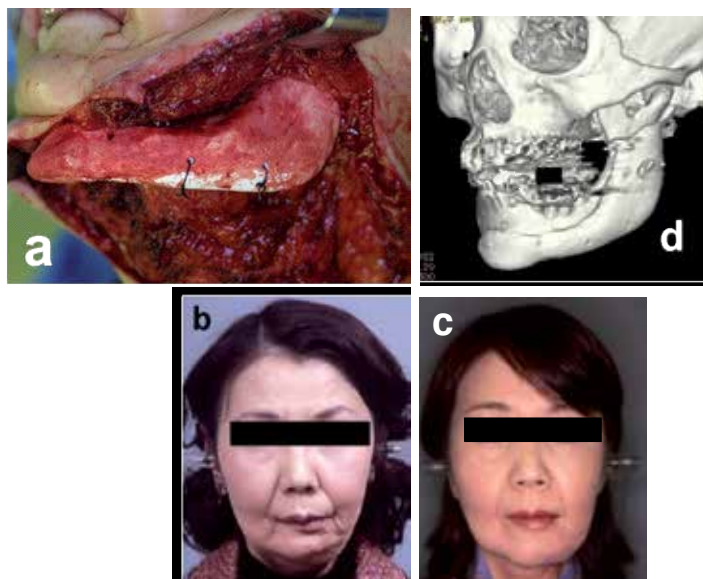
Case 1 a: During operation. b: Facial appearance of Patient 2 before surgery. c: Facial appearance at 2 year after surgery. d: 3D CT image of the left lower jaw after surgery
